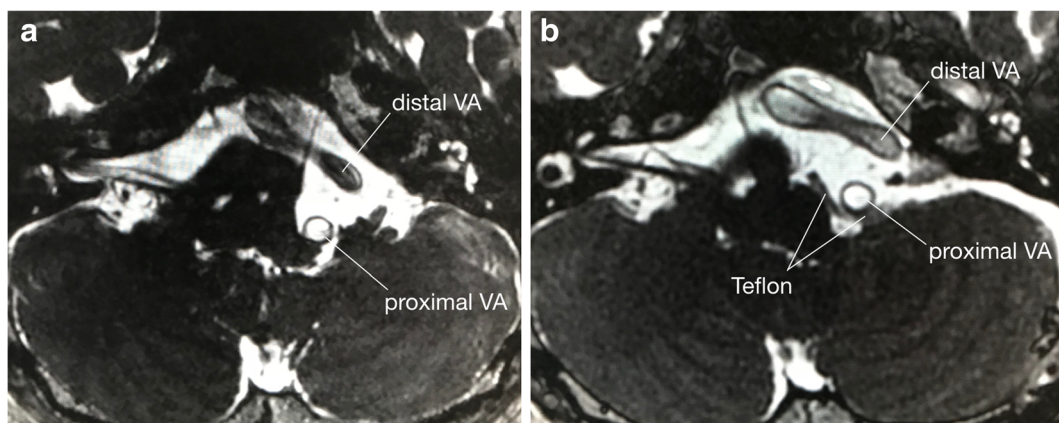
Pre- and postoperative MRI. a Preoperative axial T2-weighted MRI demonstrating the compression of the brainstem and REZ of the facial nerve by the left VA. b Postoperative axial T2-weighted MRI
